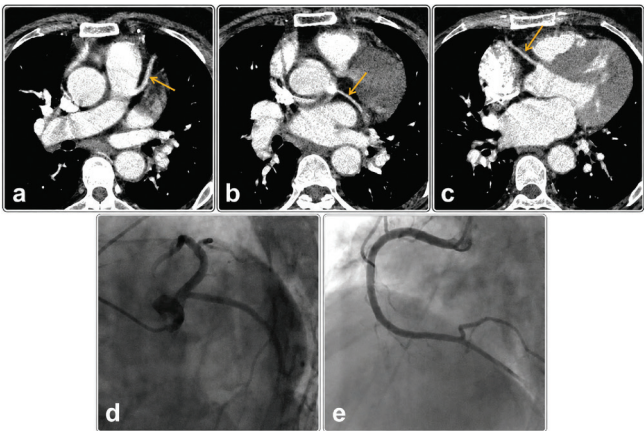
Thoracic computed tomography angiography images show normal findings in the left anterior descending artery (a), circumflex coronary artery (b), and the right coronary artery RCA (c), which are also confirmed to be normal by conventional coronary angiography (d, e)
